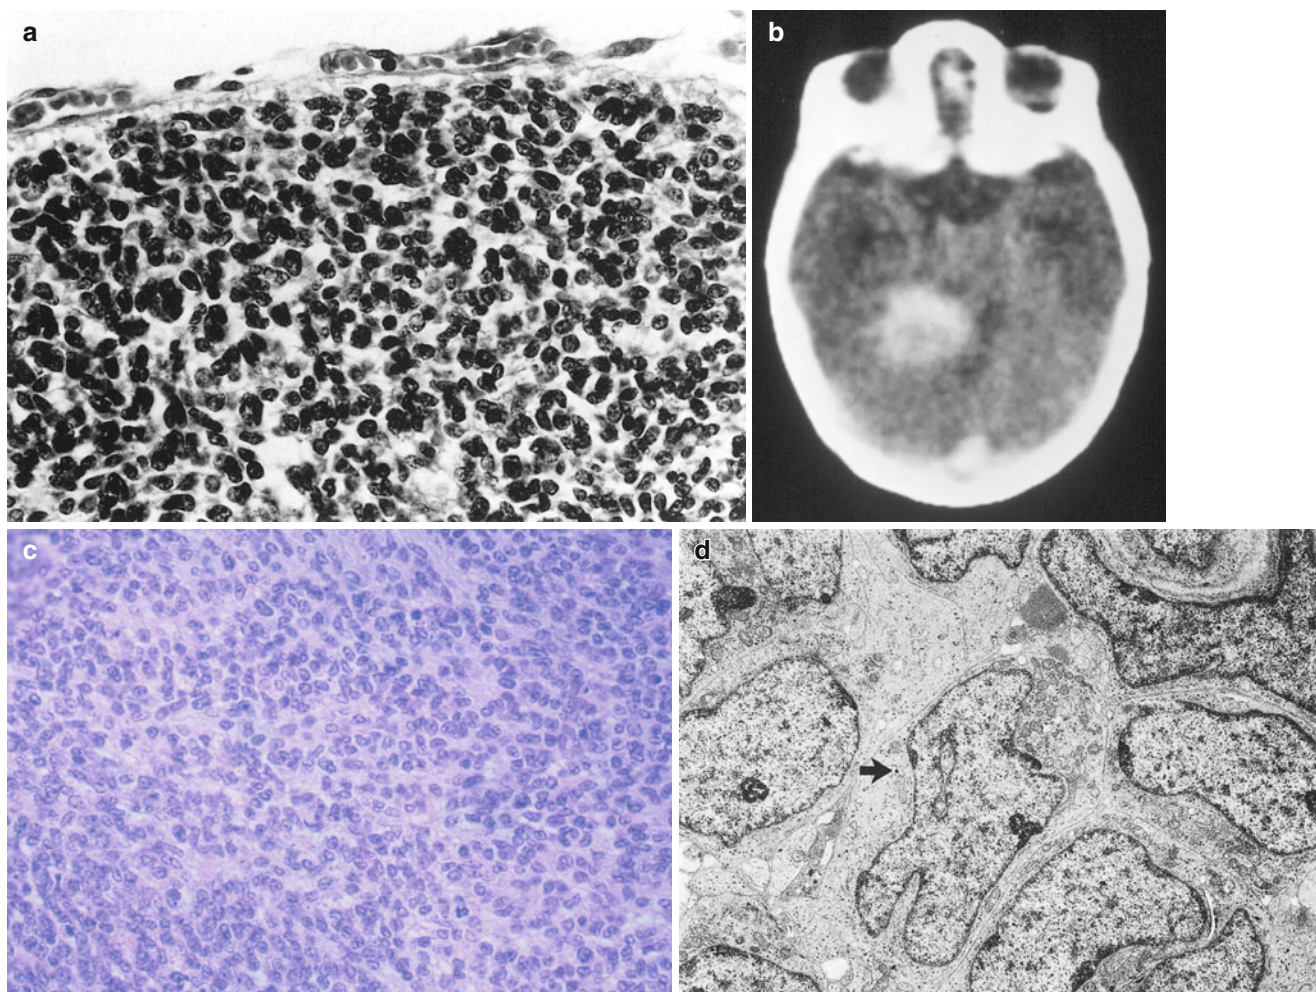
Medulloblastoma. (a) Cerebellar biopsy from a 650 g, 10 hour-old-male infant of 26 weeks gestation showing the developing external granular layer in an immature but normally otherwise brain. Superficial biopsies of the external granular layer may be misinterpreted as a tumor such as medulloblastoma on frozen section. (b) Intracranial CT scan of a newborn with a several week history of poor feeding and vomiting and terminally bulbar paresis. There is a large enhancing mass within the medial aspect of the left cerebellar
